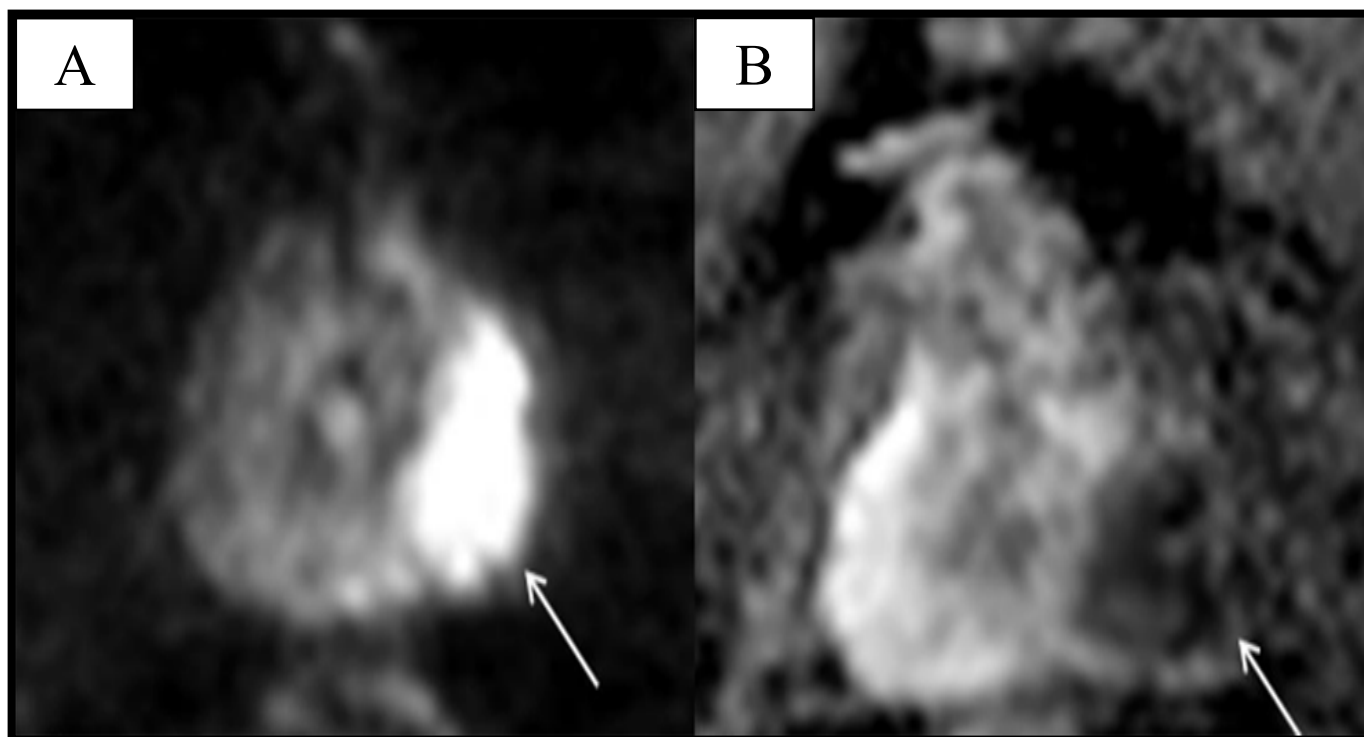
(A) DWI of PCa in the left PZ (white arrow) b1400 (B) ADC_{map} (60).
